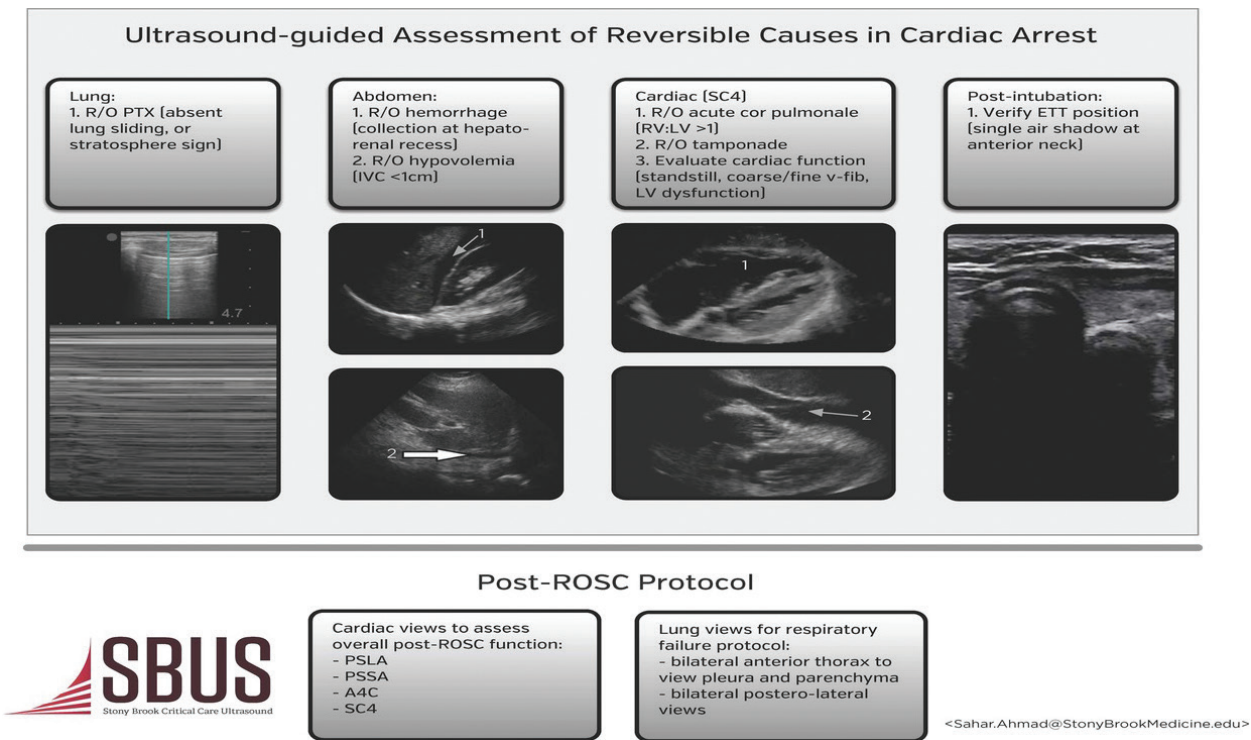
CA US protocol at Stony Brook University medical center critical care ultrasound (SBUS) program.
